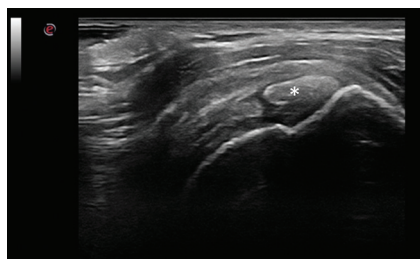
Longitudinal ultrasound image of the supraspinatus tendon with an aggregate of crystals of basic calcium crystals (*).
